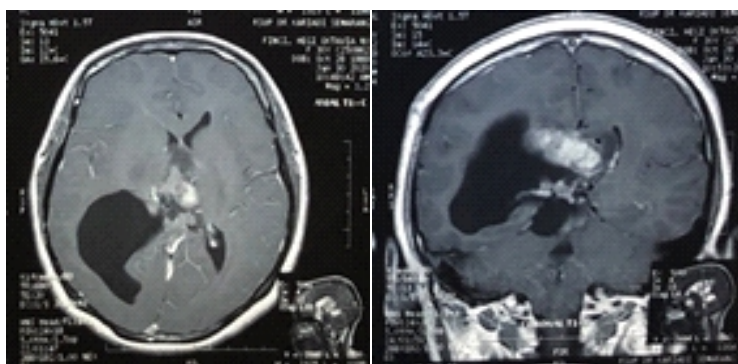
Brain MRI evaluation 3 months after radiotherapy showed slightly reduction in tumor mass (4.00 cm x 3.86 cm x 3.63 cm)
